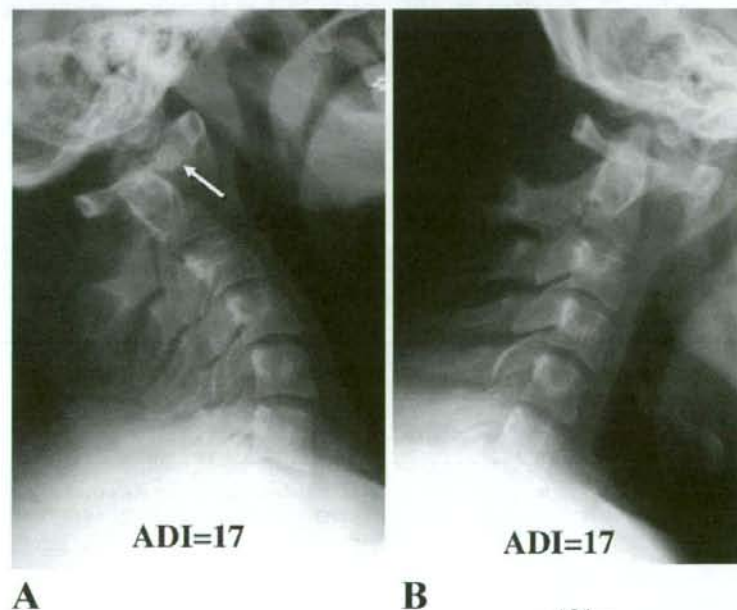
Extension (A) and flexion (B) cervical radiographs obtained at admission to our hospital (8 weeks after the onset of neck pain) show severe AAS, indicating an ADI of 17 mm. The anterior displacement of C1 was not reduced, even with the extension of the subject's neck (arrow).
